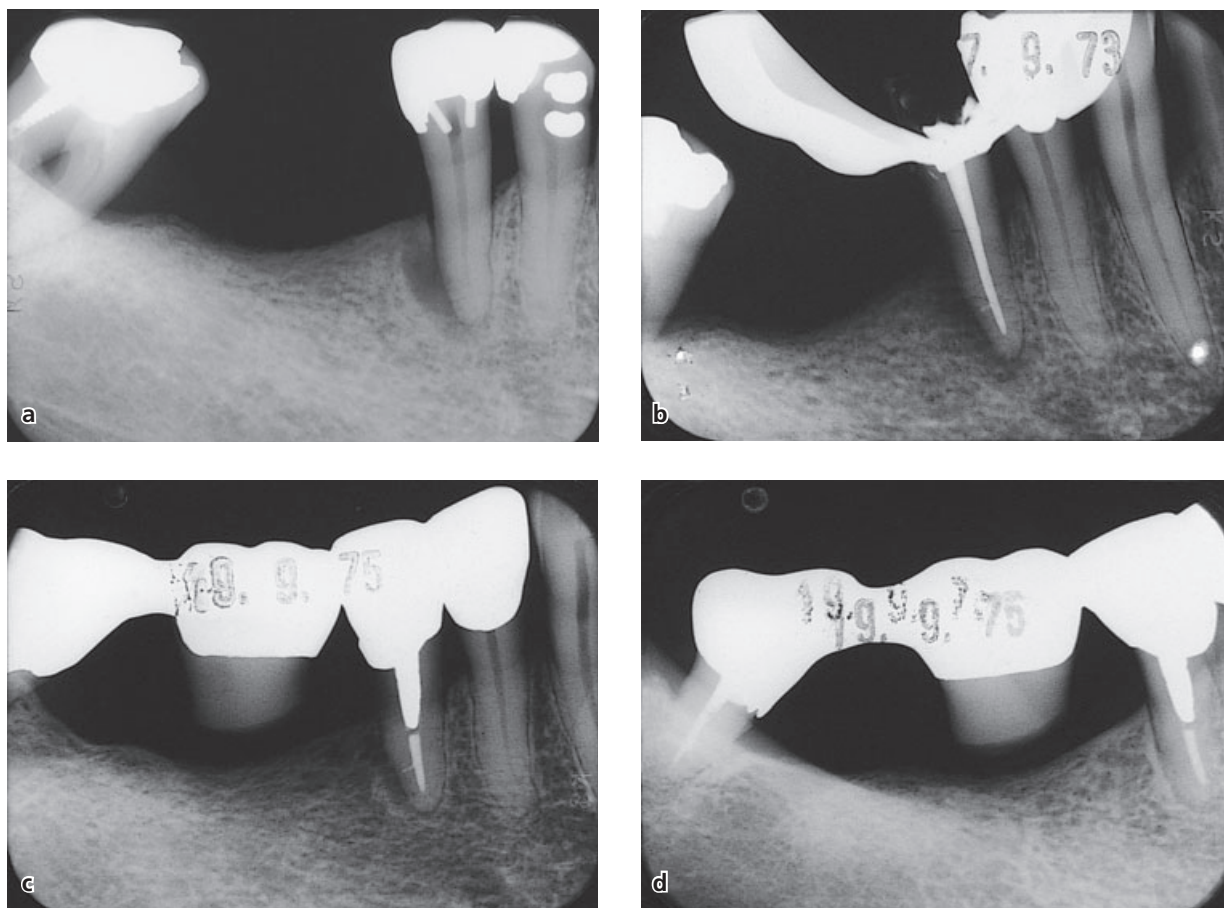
(a) A radiolucent area along the distal root surface of tooth #45 is combined with horizontal loss of marginal bone. (b) As the pulp was non-vital it was subjected to endodontic treatment. After prosthetic treatment (c) the 2-year recall radiograph (d) shows bone fill in the previous angular defect. Careful examination of the radiographs in (b) and (c) reveals a filled accessory canal communicating with the lateral bone defect.
